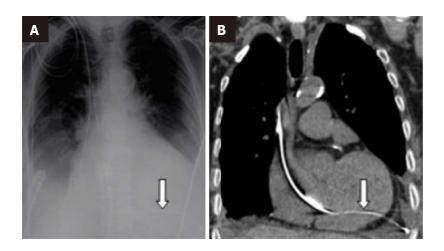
Chest radiography and computed tomography. A: Chest radiography (arrow); B: Computed tomography (arrow) showing that the pacing wire had traversed from the inter-ventricular septum into the left ventricle, and through the left ventricular myocardium to lie within the left pleura.
